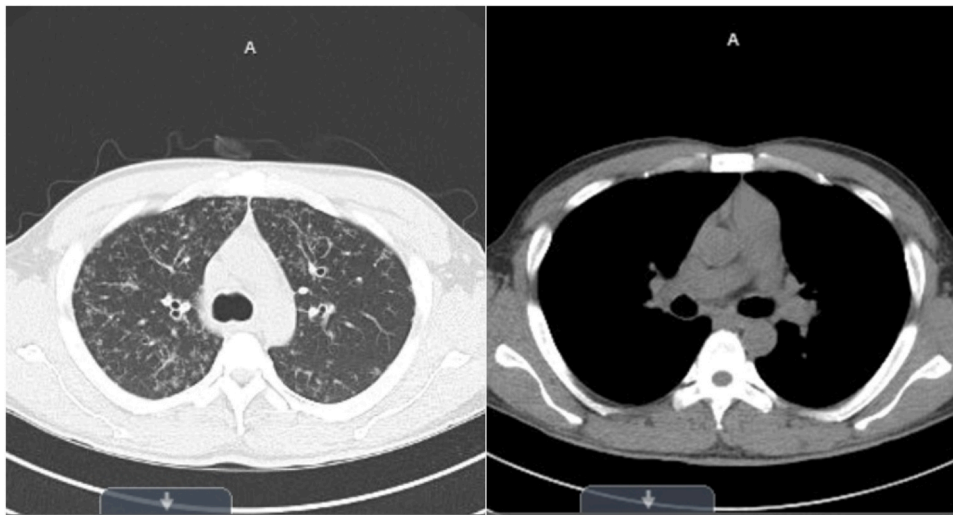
High resolution CT scan of the thorax showing lung infiltrates and hilar lymphadenopathy. Left – lung window; Right – mediastinal window.
